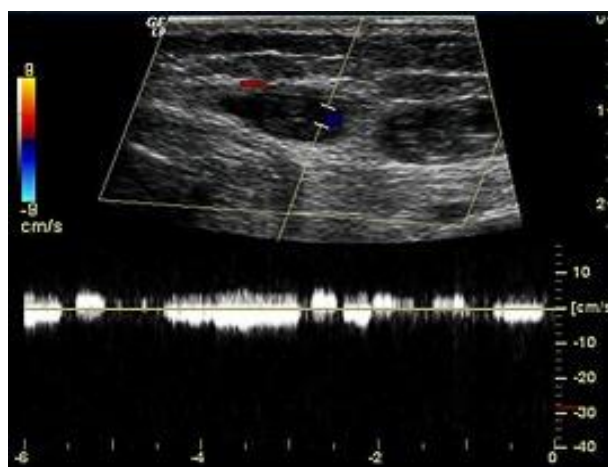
Duplex scanning of angiomatous tissues. Venous caverns with low-velocity blood flow based on the Doppler curve data
